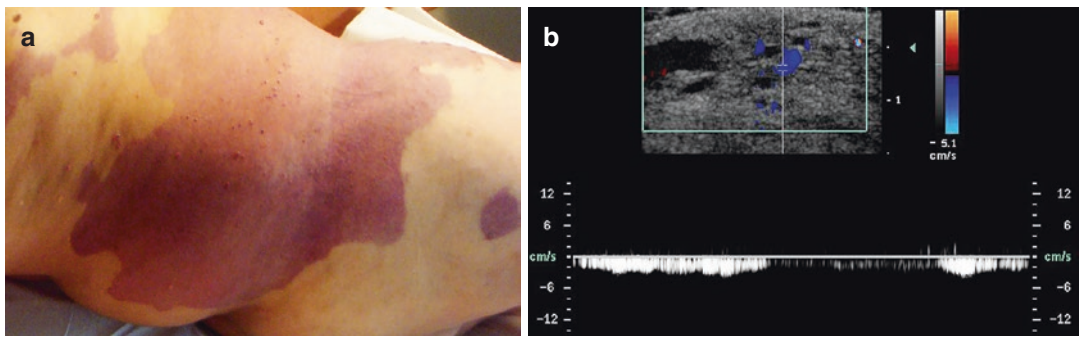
Proteus syndrome. (a) Clinical image. (b) Color Doppler spectral curve analysis of the right side of the abdominal wall demonstrates multiple lacunar and tubular hypodermal areas showing venous flow in some of them
